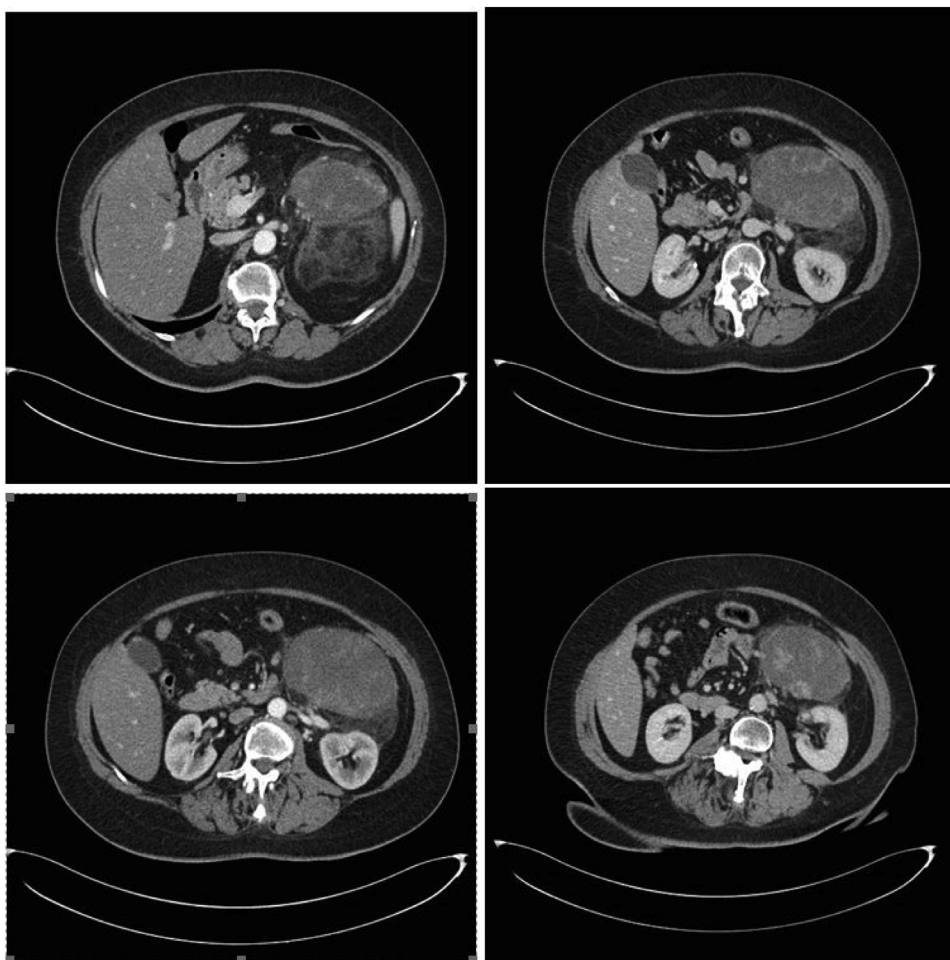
CT abdominal scan showed a voluminous solid oval mass (11.2 cm × 7.5 cm × 12 cm) in the left perirenal space with dislocation of the kidney and in continuity with the anterior renal fascia. After iodinated-contrast we observed a progressive, inhomogeneous enhancement of the lesion with peripheral vascularization.
